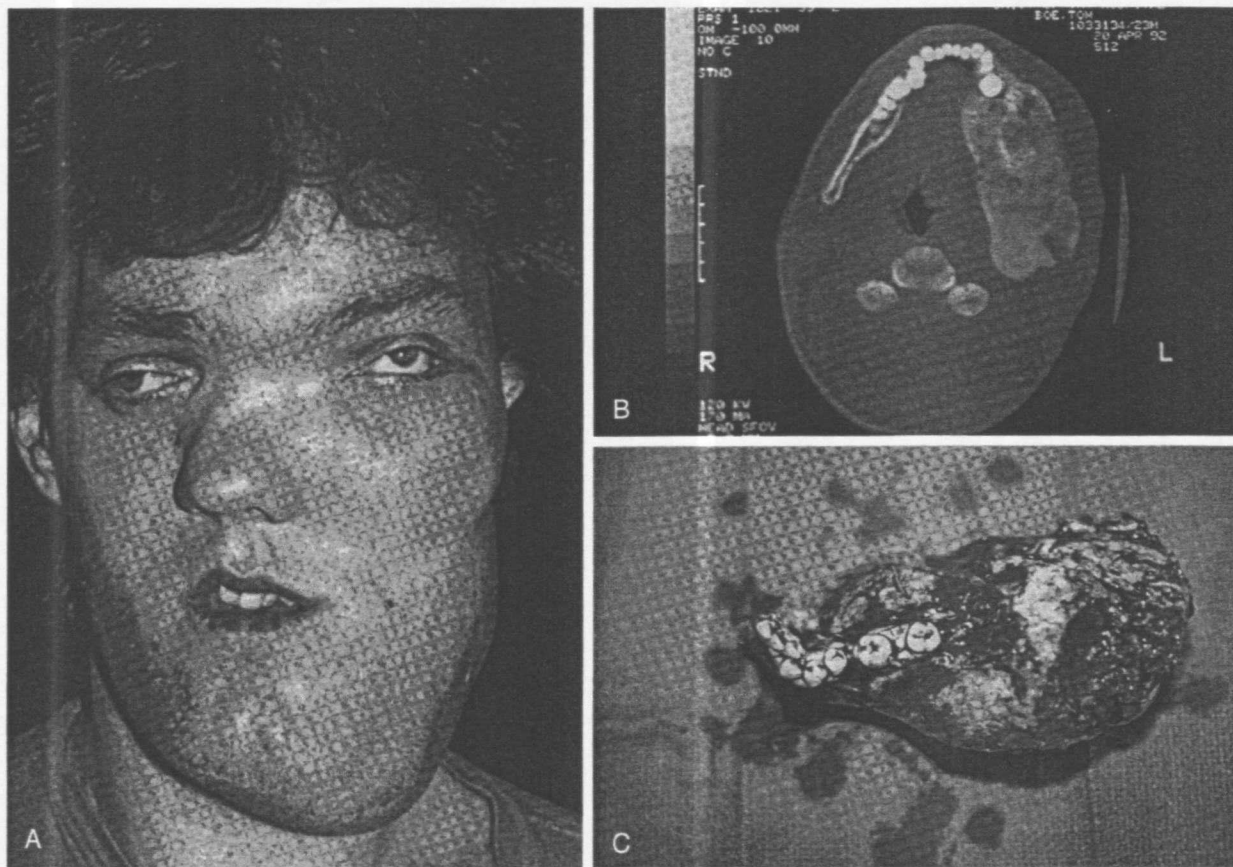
A, Patient with FD, involvement of the left hemimandible resulting in severe facial distortion. B, Computed tomographic scan of the diseased hemimandible. C, Exposed diseased bone via Risdon incision.
